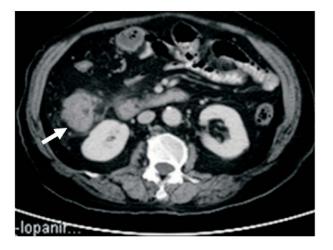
Abdominal CT scan showed ascending colon cancer, stage: cT3N2aM0 (arrow: tumor site).
